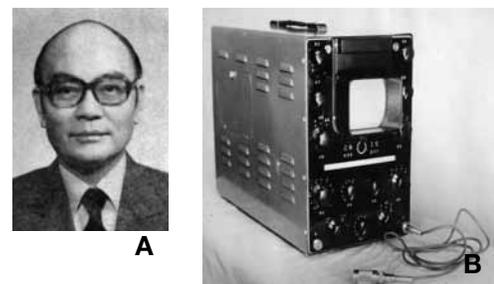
(A) Shih An (courtesy XF Wang) and (B) China’s earliest ultrasonic diagnostic device, the A-mode scanner, made in Jiangnan Shipyard in Shanghai and used in 1958 by An for diagnosing various diseases in patients at the Shanghai Sixth People’s Hospital (courtesy B Hu and XF Wang).
